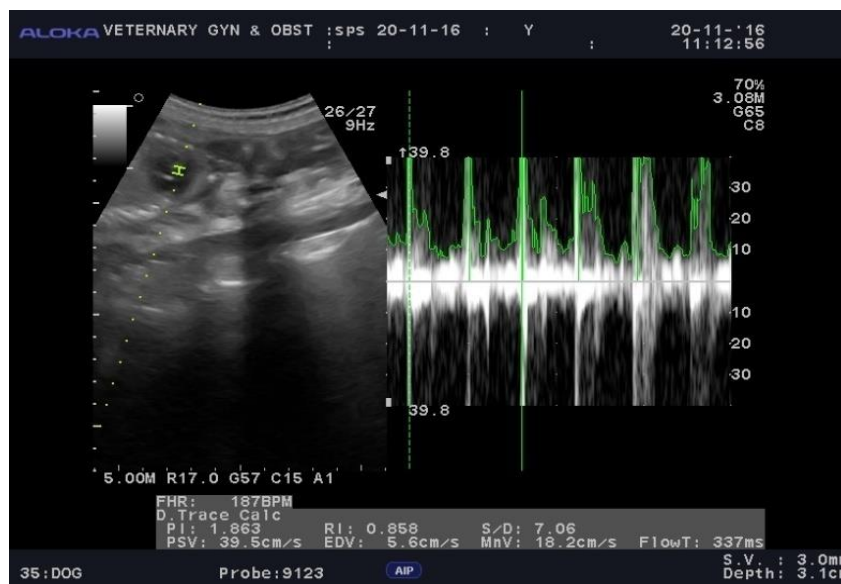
Determination of fetal heart rate by ultrasound scan
